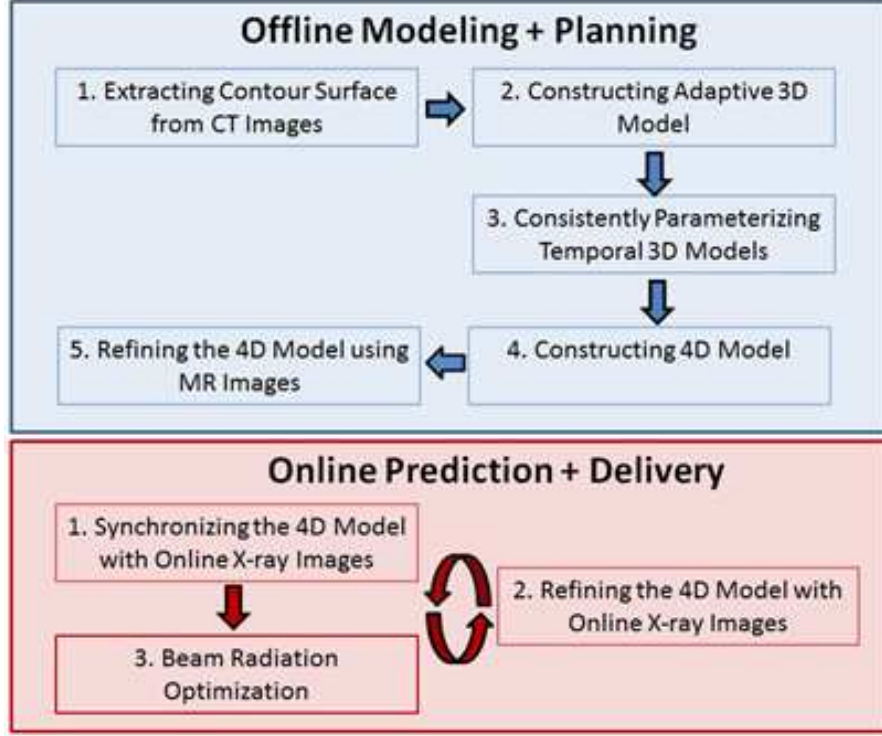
Two phases in the computational framework. The first phase, offline modeling and planning, emphasizes radiotherapy planning and is based on CT and magnetic resonance (MR) scans. The second phase focuses on online prediction and treatment delivery. Real-time scanned 2D images aid in synchronizing and refining the 4D model, which the system uses to predict the tumor’s trajectory and geometry and guide treatment delivery.
